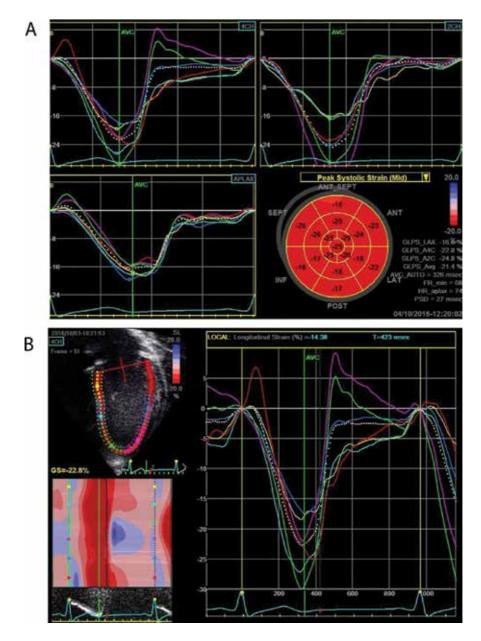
(A) Longitudinal strain analysis of the left ventricle, with both regional and global longitudinal strain reported. The six segment strain curves from the apical 4-chamber, apical 2-chamber and apical long axis are shown, as well as a "bullseye" view overlaying the longitudinal strain for each segment. (B) Segmental strain for the apical 4-chamber view, including contours of the left ventricle. Global longitudinal strain of the entire 4-chamber slice is normal at -22.8%.
